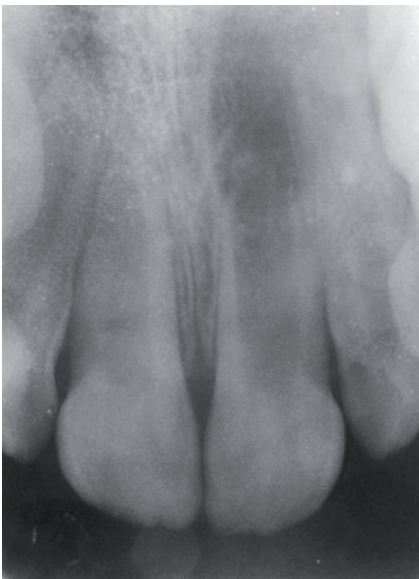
Pre-operative x-ray (February 2014).
